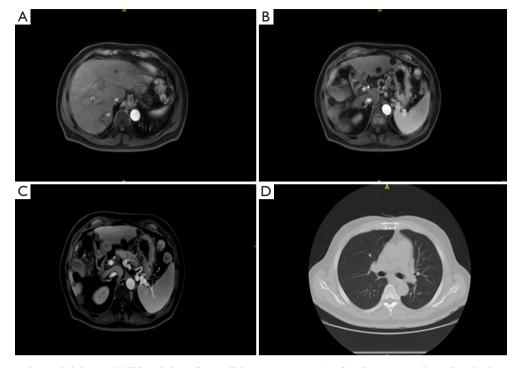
Contrast-enhanced abdominal MRI and chest CT on February 20, 2022. (A-C) The imaging showed multiple inactive intrahepatic lesions but no enlarged retroperitoneal lymph nodes. (D) The previous intrapulmonary metastasis had disappeared. MRI, magnetic resonance imaging; CT, computed tomography.
